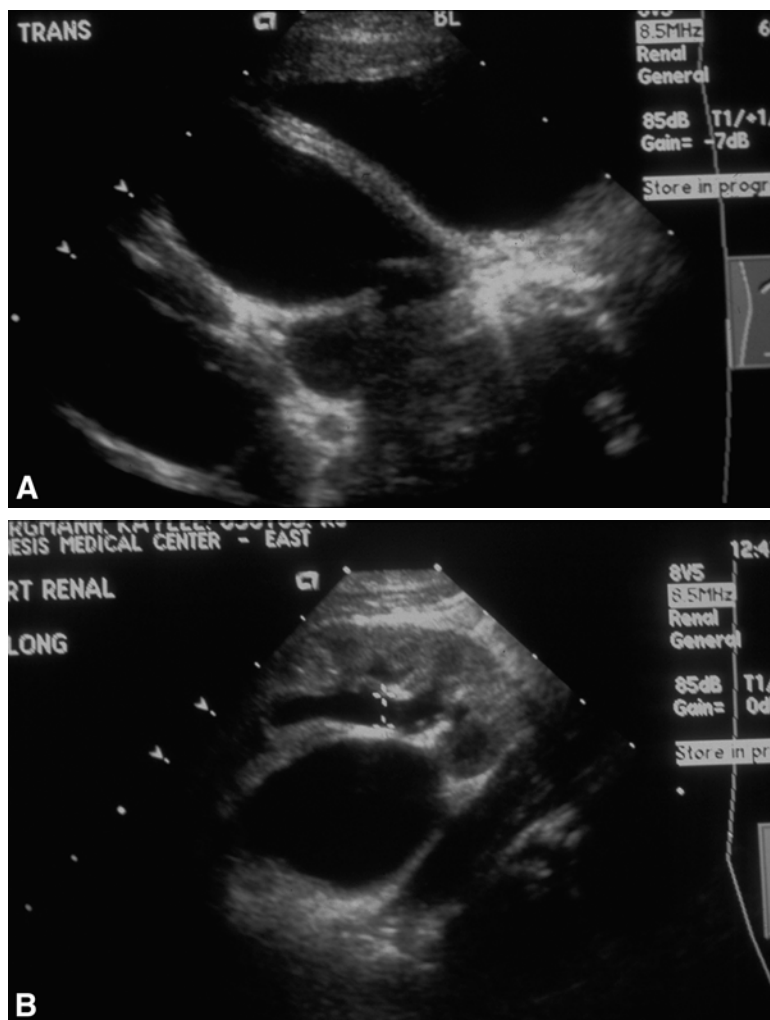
(A) Pelvic ultrasound demonstrating massively dilated ectopic ureter posterior to bladder. (B) Renal ultrasound in same patient demonstrating severe hydronephrosis of upper pole and mild hydronephrosis of lower pole.
